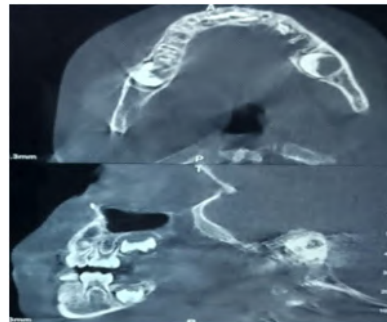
CBCT shows well defined vertical alveolar bone loss around primary molars
